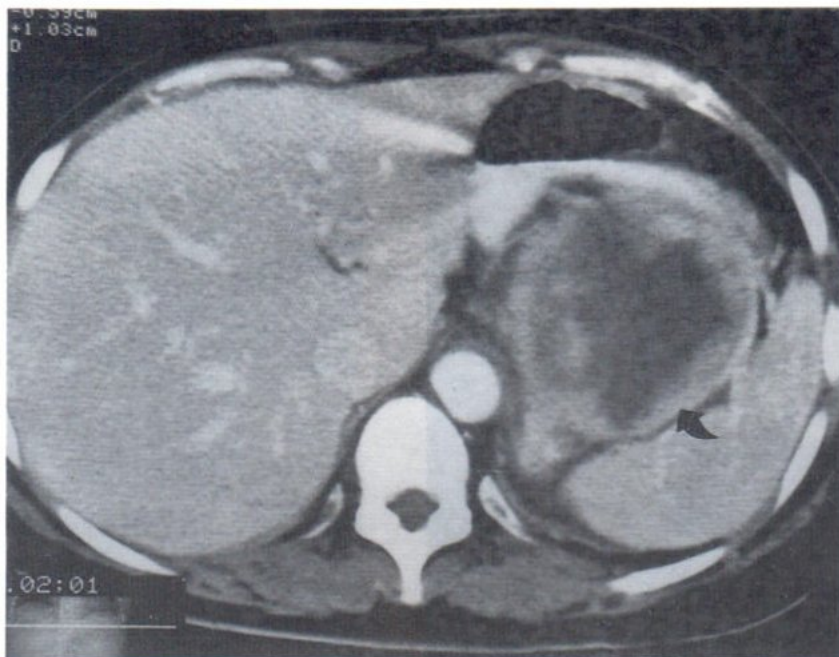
I.V. contrast CT scan of the mass showed rim enhancement, central necrosis and enhanced non-necrotic part.
